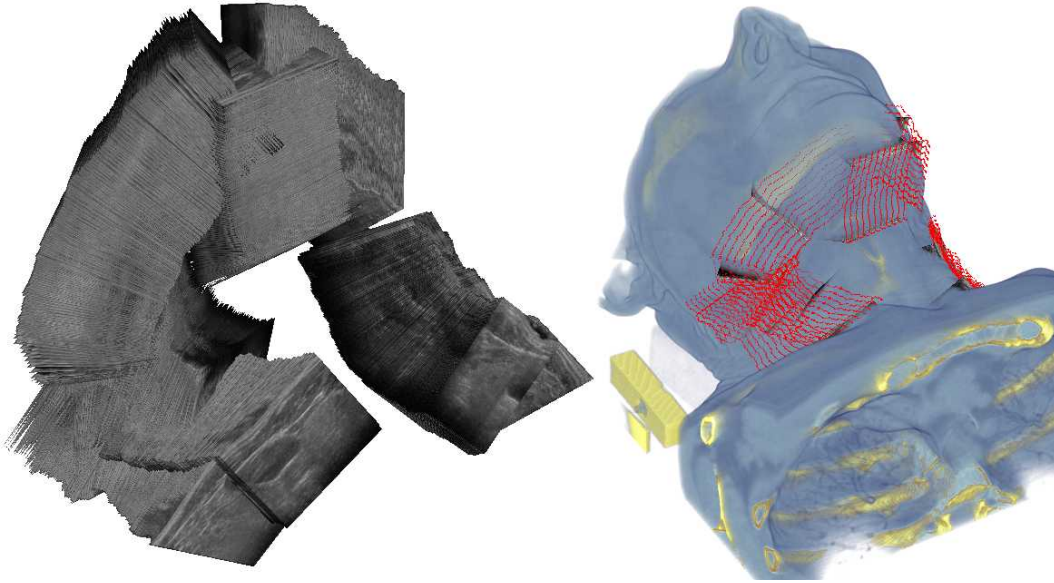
Left: Spatial overview of all ultrasound images of Patient 3. Right: Extracted surface points (red) with volume rendering of CT and some individual ultrasound slices.
